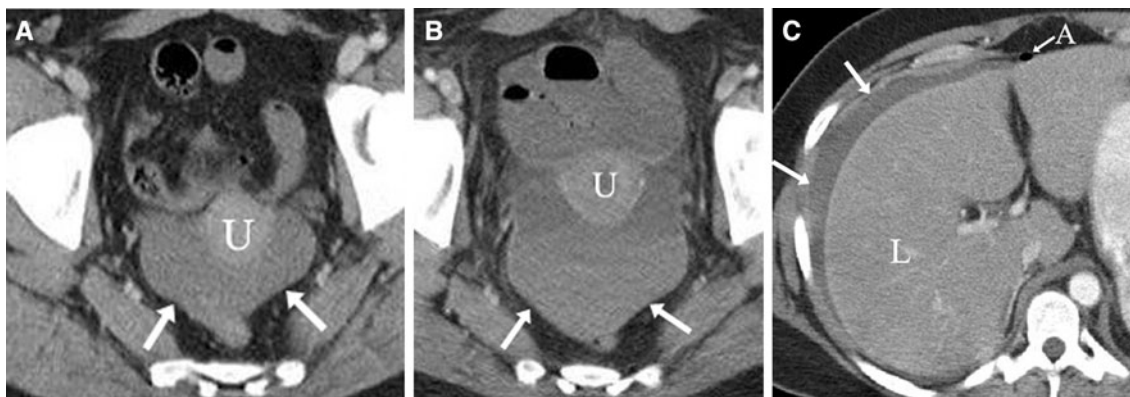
A 42-year-old female status post-blunt abdominal trauma. A Axial contrast-enhanced CT of the pelvis demonstrated a moderate amount of isolated free fluid (*arrows*) adjacent to the uterus (*U*) with attenuation 41 HU. No other CT features of abdominal organ injury were identified (not shown). B Axial contrast-enhanced CT of the deep pelvis 23 h
